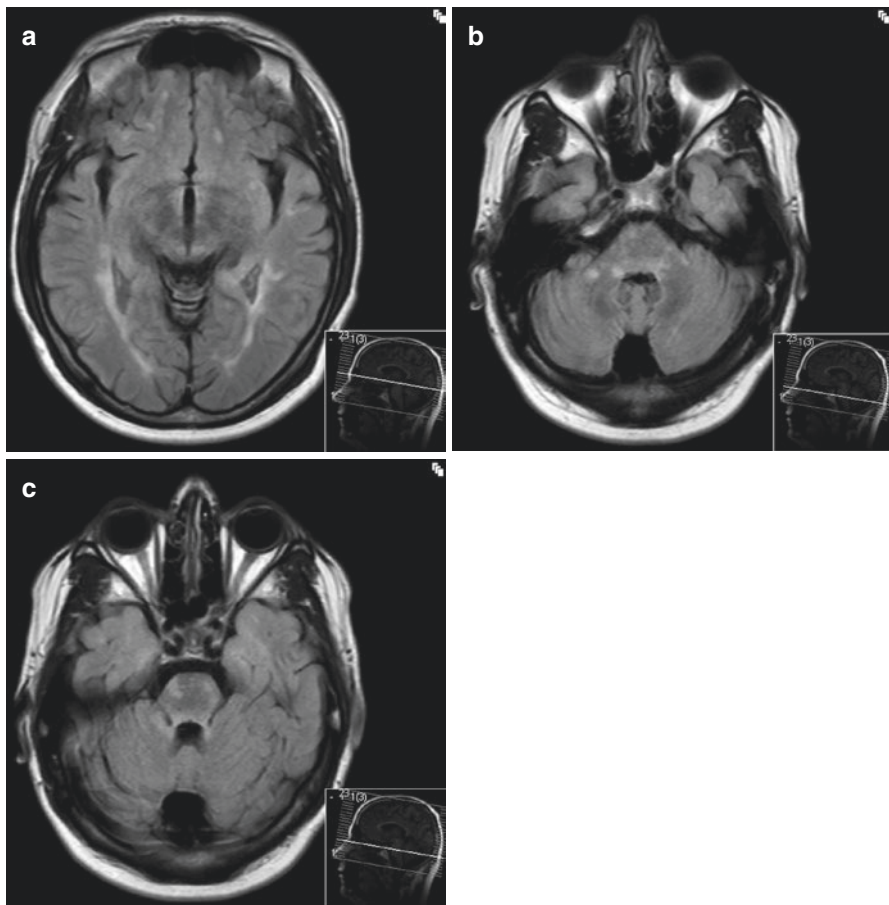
Axial FLAIR MRI scan of brain showing numerous white matter lesions typical of that seen in multiple sclerosis (a) in a periventricular pattern and (b, c) within the brain stem
